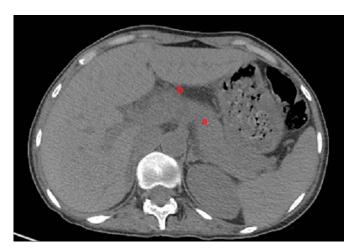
Abdominal computed tomography without contrast demonstrating diffuse enlargement of the pancreas (A) associated with peripancreatic fluid effusion and fat stranding (B) consistent with acute interstitial pancreatitis.
